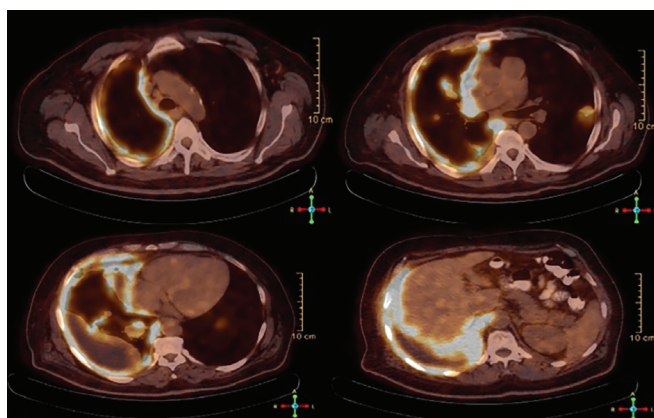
Positron emission computed tomography of the case
